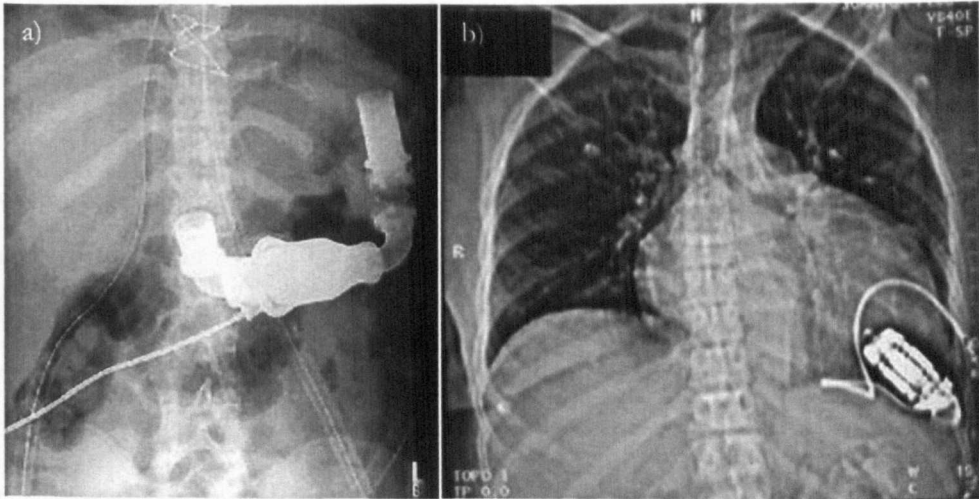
X-rays of implanted LVADs. a) Thoratec HeartMate® II [54] b) Jarvik 2000 FlowMaker® [55].
